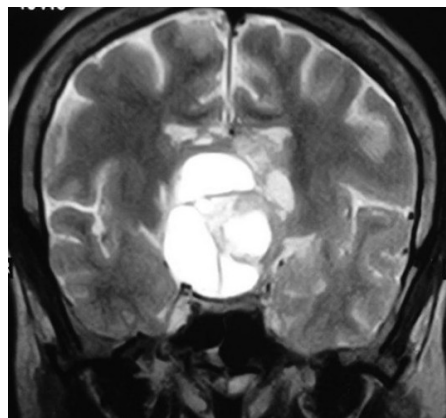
Sagittal and coronal images of MRI of brain shows sella and supra sellar complex mass having cystic and solid components
